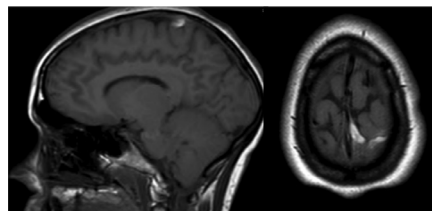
MRI: Isolated cortical venous thrombosis in the left parietal convexity
